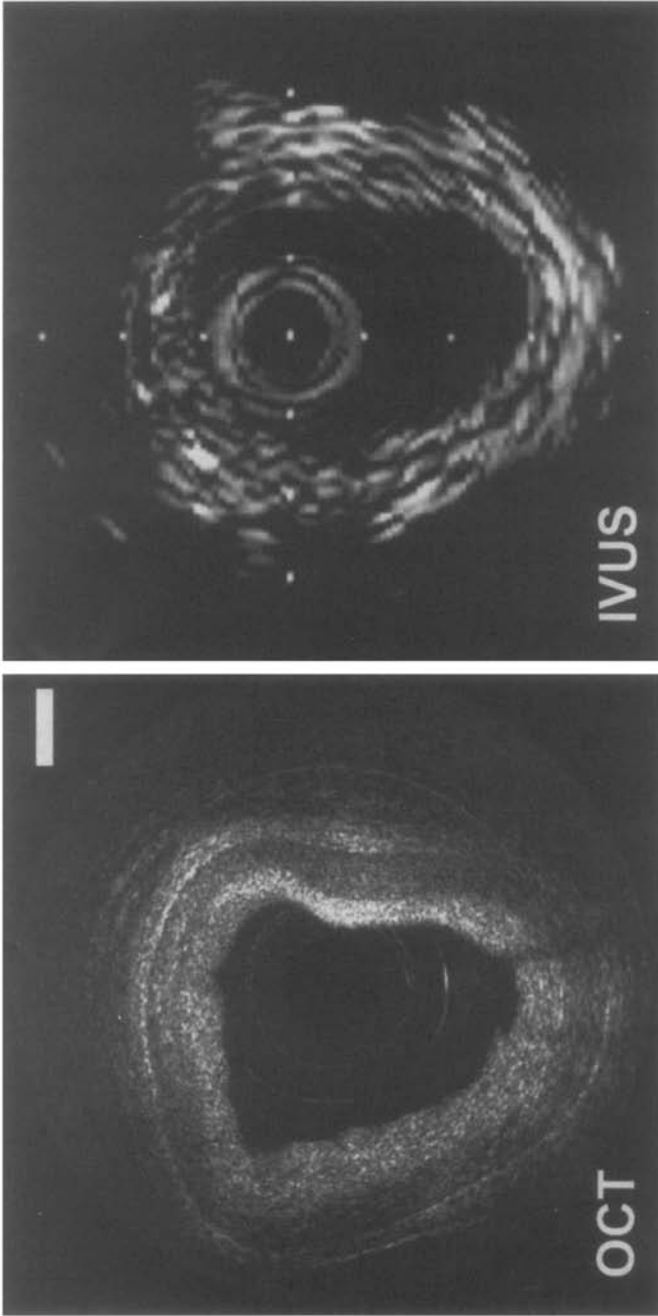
Comparison images of *in vitro* human saphenous vein using the OCT catheter-endoscope (*left*) and a standard 30 MHz intravascular ultrasound (IVUS) catheter (*right*) during coronary artery intimal hyperplasia.
